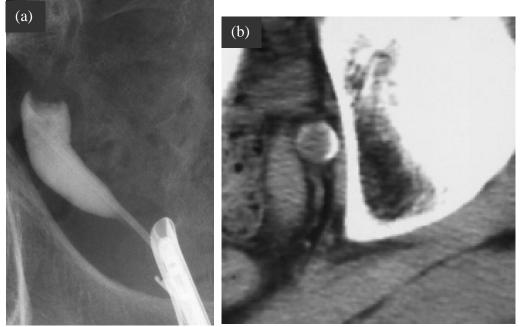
Retrograde ureterography (a) and CT (b) imaging of organ-confined ureteral tumor. Retrograde ureterography shows papillary tumor and CT imaging shows intraureteral tumor.
